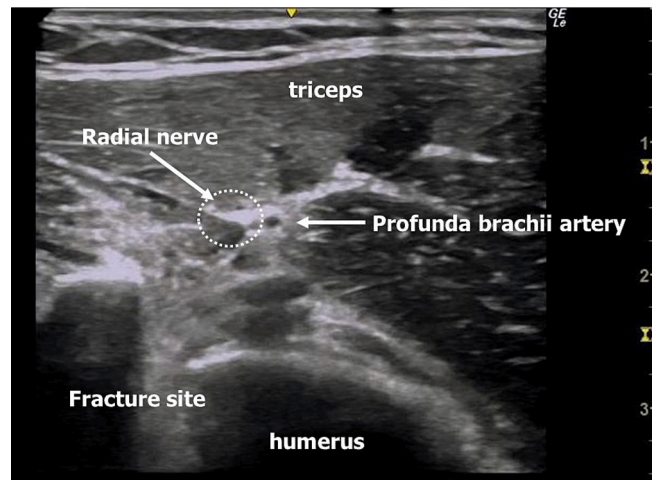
Ultrasonography and anatomical caption of the humerus shaft and radial nerve at 5 cm distal from the fracture site. From this point, we could not trace the radial nerve course close to the fracture site.
